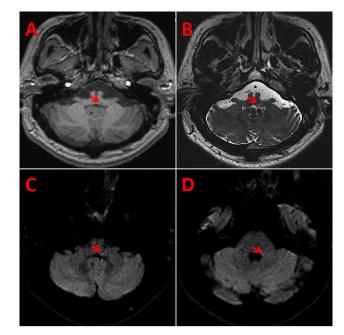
MRI results of patient 1. The MRI showed low T1-MPRAGE, high T2 (3D-CISS), and DWI signals in the left medulla (A–C). Reexamination of brain MRI revealed high DWI signals in the left brachium pontis (D).
